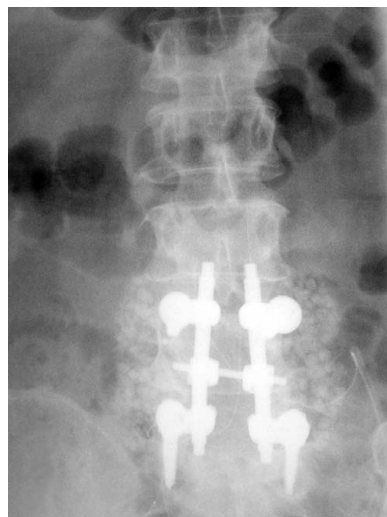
Initial postoperative anteroposterior radiograph of an L4–S1 posterior decompression and posterior lumbar fusion with lamina chips plus OsteoSet® 5 mL.
